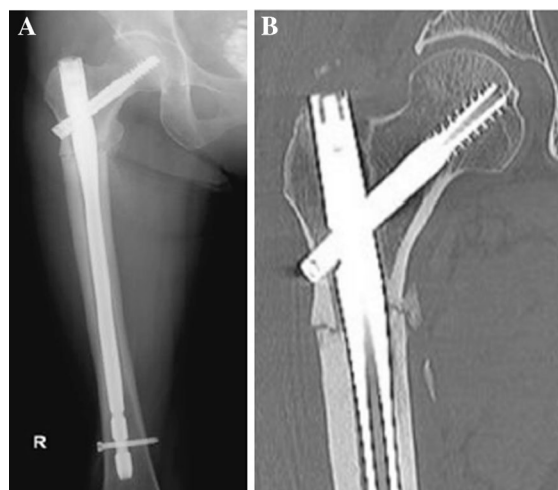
Radiograph and CT imaging after 3 months of LIPUS therapy. a Radiograph imaging after 3 months of LIPUS therapy shows delayed union at the fracture site. b CT imaging after 3 months of LIPUS therapy shows delayed union at the fracture site. *CT* computerized tomography, *LIPUS* low-intensity pulsed ultrasonography
